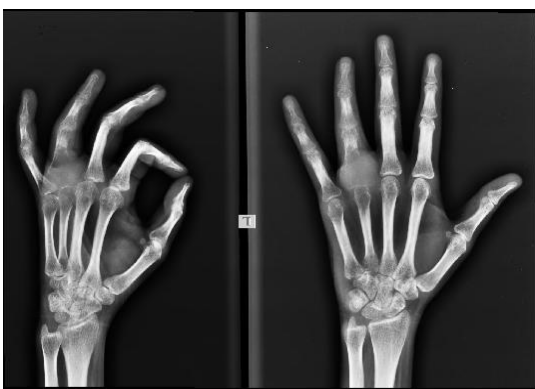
Xray AP and Lateral view of hand showing lytic expansile lesion in proximal shaft of ring finger with erosion and destruction of the overlying cortex
